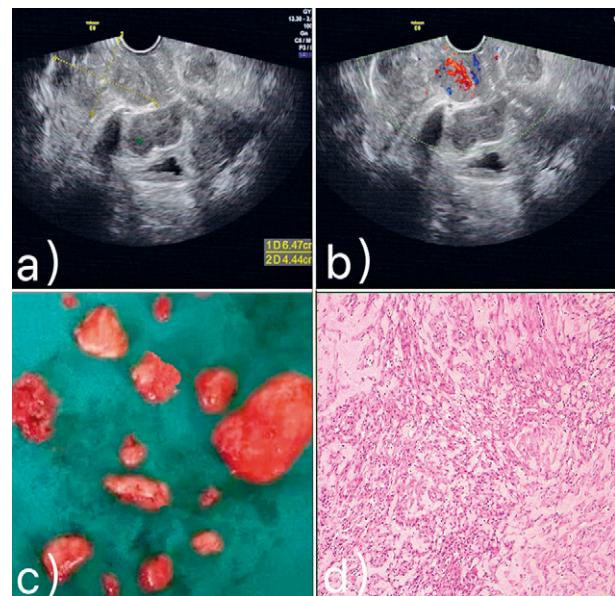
a) Transvaginal Color Doppler ultrasound showed that there were multiple solid hypoechoic masses around the vagina, some of which fused into clusters. The largest one was about 6.4x4.4 cm, with unclear boundary with vagina, irregular shape, and uneven internal echo; b) Abundant blood flow signals were observed in and around the mass, RI: 0.89; c) More than 10 irregularly shaped masses were removed during the operation, the largest being 7x3x2 cm; d) Postoperative pathological results showed urethral leiomyoma.
